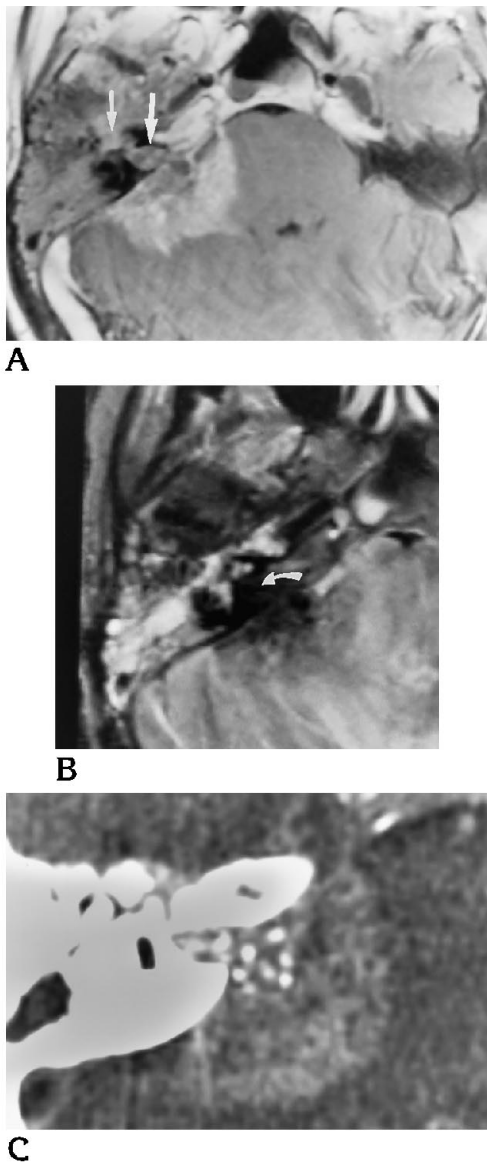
A, Axial T1-weighted contrast-enhanced magnetic resonance study demonstrates a heterogeneously enhancing mass arising within the right cerebellopontine angle extending into the internal auditory canal (*large arrow*) with involvement of the labyrinthine portion of the facial nerve (*small arrow*). The medial margin suggests brain stem invasion, confirmed at surgery.
